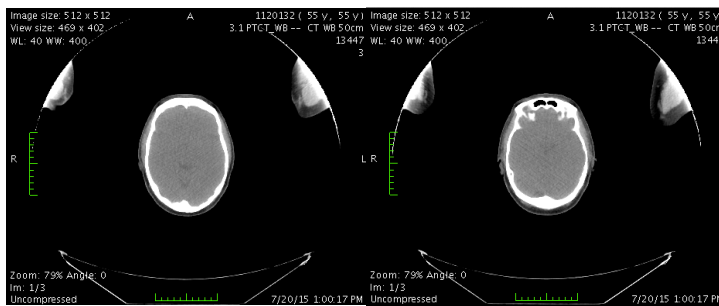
CT/PT scan whole body – July 2015
